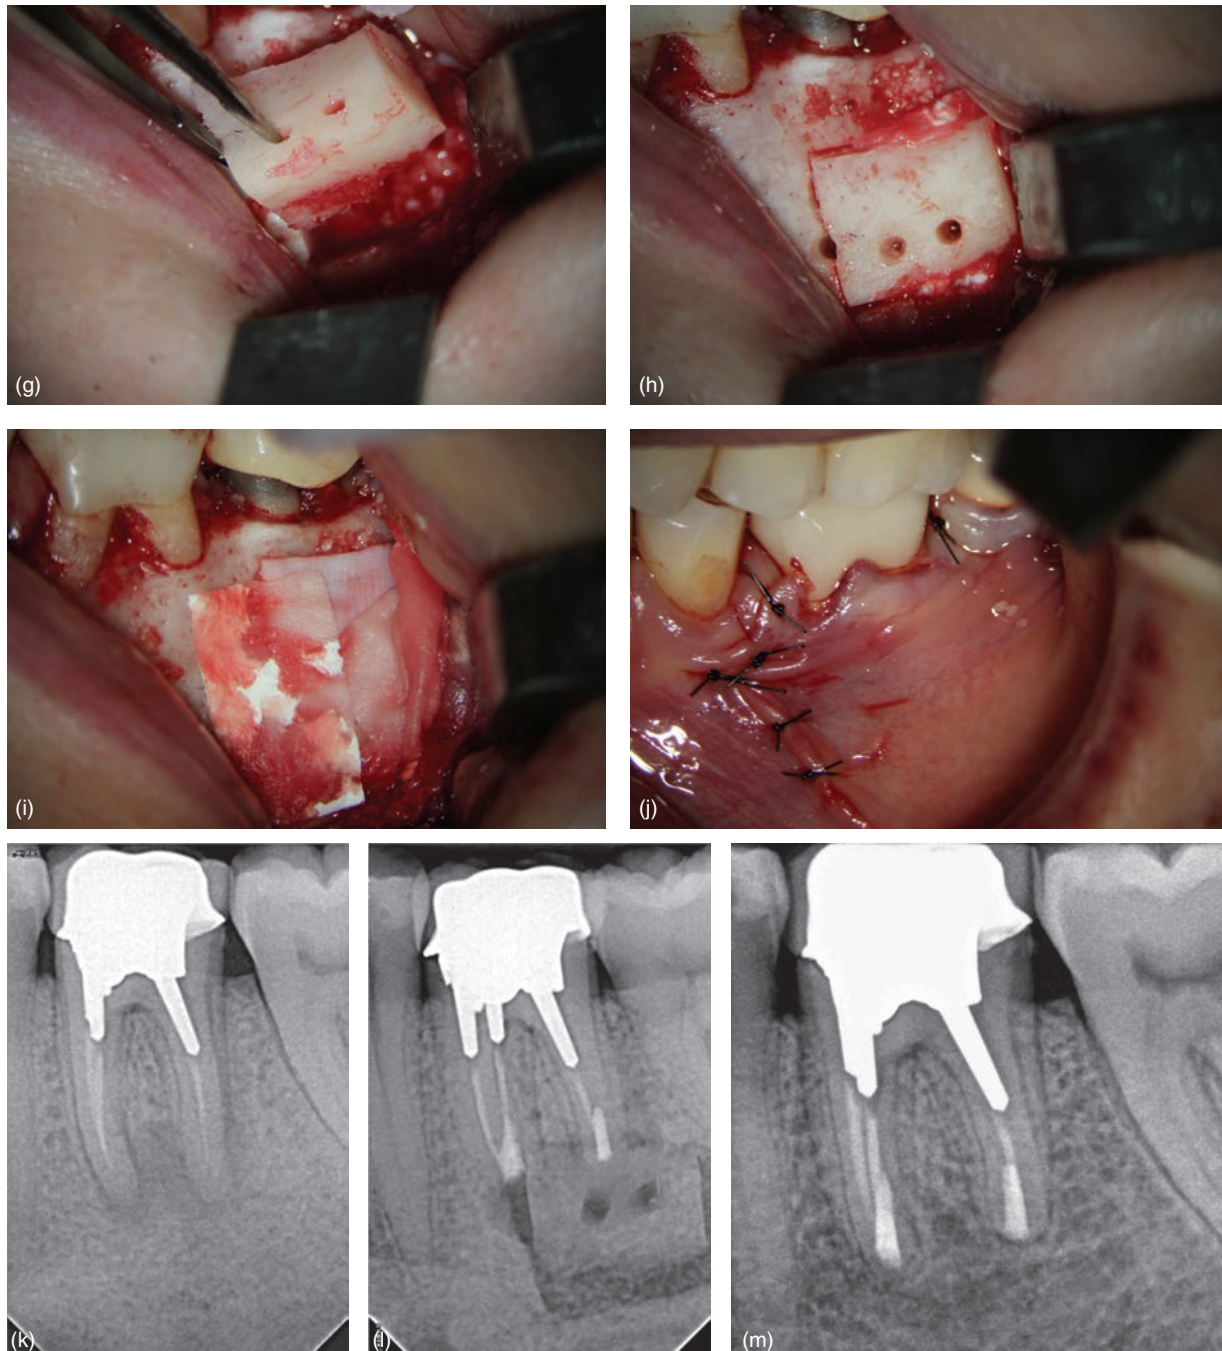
(Continued) (g) Bone window being replaced; (h) bone window replaced wedging in collagen membrane; (i) two collagen membranes placed over the bone window; (j) sutures placed; (k) pre operative radiograph; (l) post operative radiograph; (m) three year recall radiograph.
